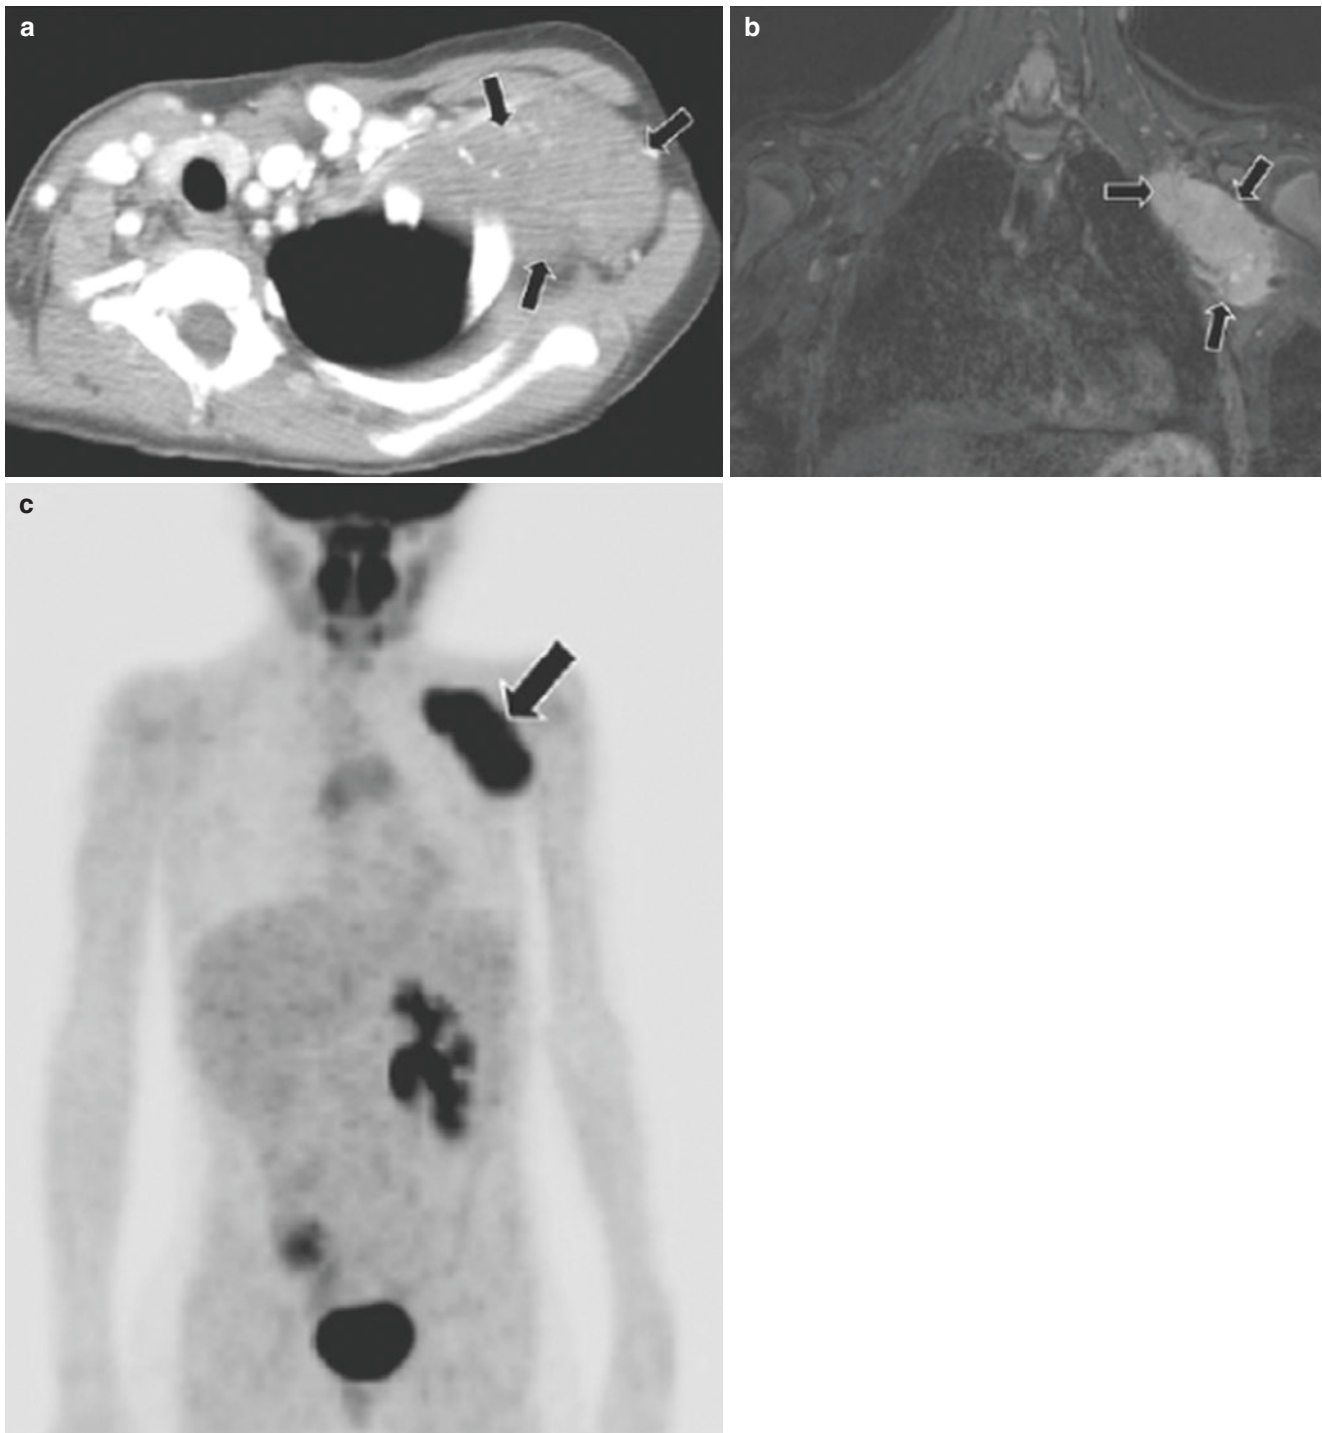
A 6-year-old girl who presented with left chest and arm pain. Surgical pathology of the left chest wall mass was consistent with rhabdomyosarcoma (RMS). (a) Enhanced axial CT image shows a large heterogeneously enhancing mass (arrows) located in the left upper chest wall. (b) Coronal STIR MR image demonstrates a large left
